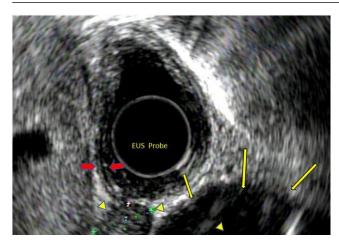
Endoscopic Ultrasound image showing a well-defined hypoechoic 8.7 mm X 8.3 mm round "plump" lymph node (arrowheads) next to the esophageal wall (red arrows) and adjacent to the aorta (yellow arrows). Image courtesy of the University of Massachusetts Medical School, Department of Medicine, Division of Gastroenterology.
